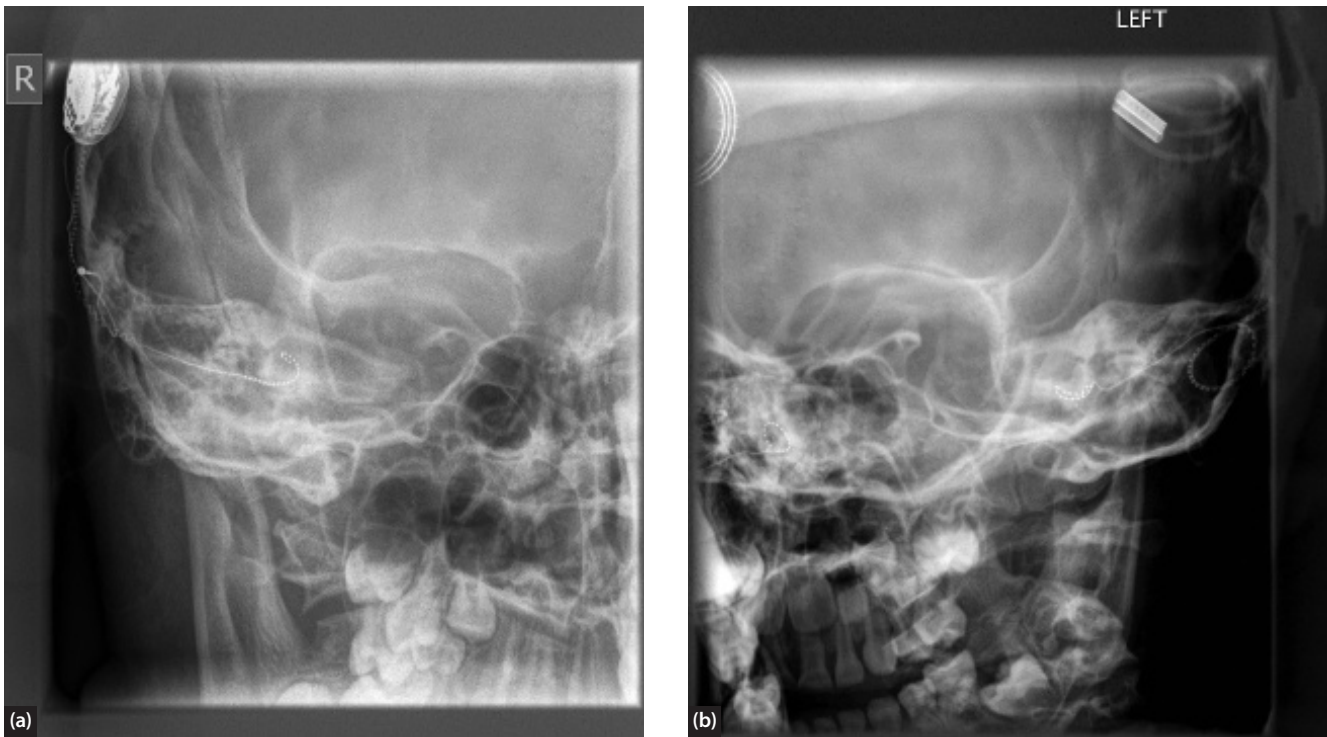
Plain skull X-rays showing (a) tip rollover of the distal electrode (note also incomplete electrode) and (b) more significant fold-over of the electrode.
